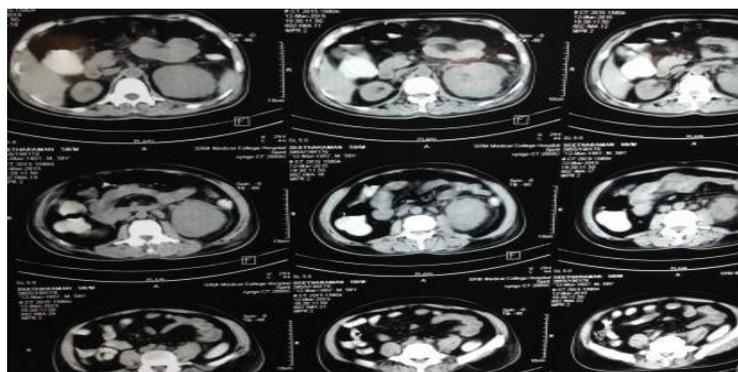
CT abdomen showing enlarged left kidney with perinephric fluid
